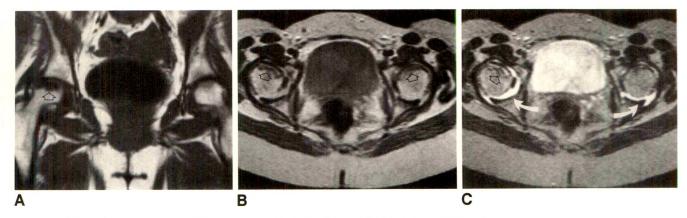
MR imaging of avascular necrosis of femoral heads in a 33-year-old man with hemoglobin SC disease.
